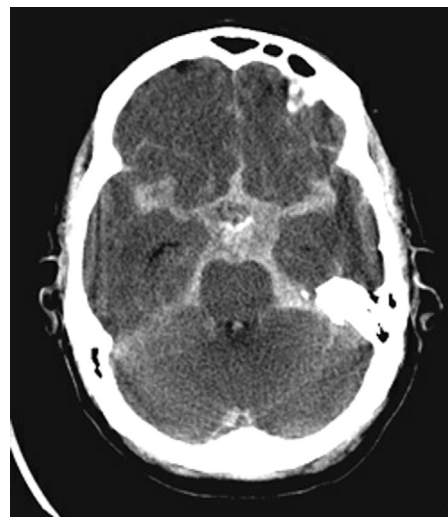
■ Computed tomography scan of acute subarachnoid hemorrhage, with a thick layer of hyperdense blood filling the basal cisterns.
